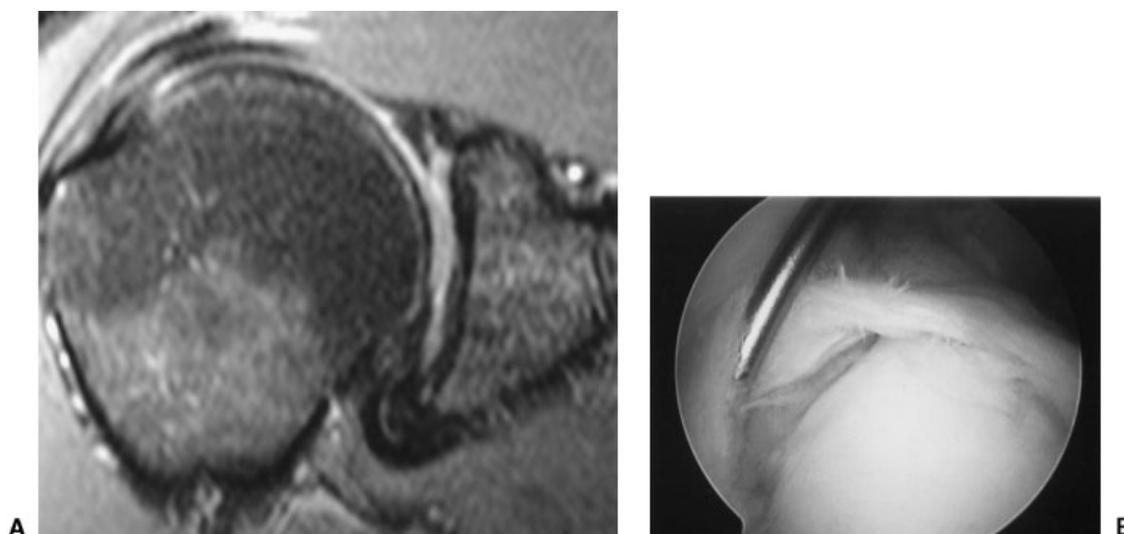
(A) Standard coronal magnetic resonance image shows abnormal signal within the substance of the superior labrum, consistent with superior labrum anterior and posterior pathology. (B) Corresponding arthroscopic image shows the irregular and frayed appearance of the superior labral tissue, confirming the imaging abnormality.
